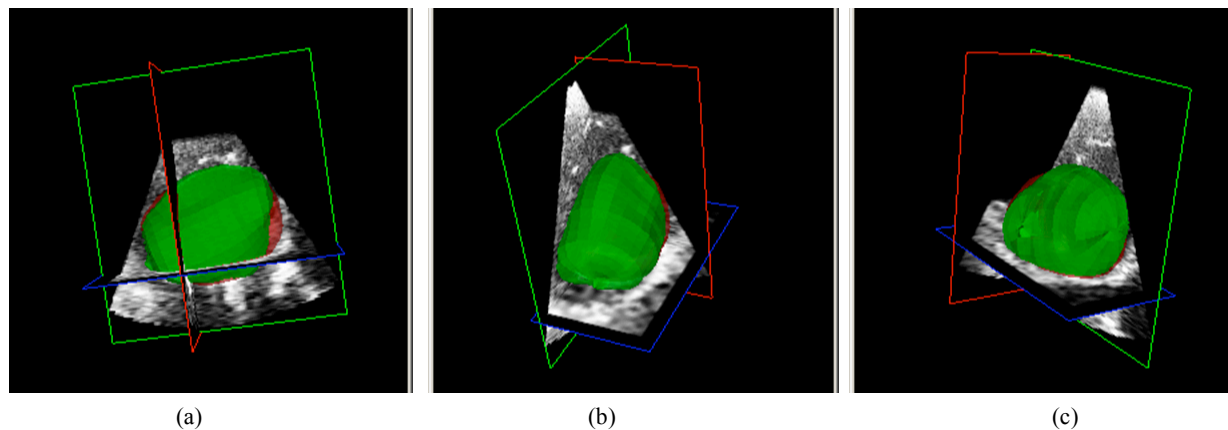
Comparison of clinical data between an automated method (red) and manual tracing (green) on one ultrasound frame of the left ventricle of a human heart at three different view angles (a-c).
